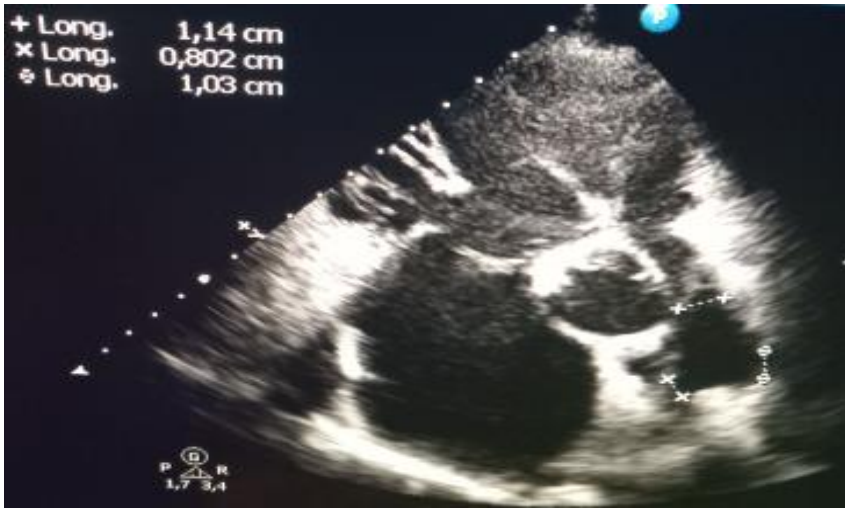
Parasternal short-axis view revealing hypoplastic pulmonary artery with dysplastic valve and severe stenosis.
